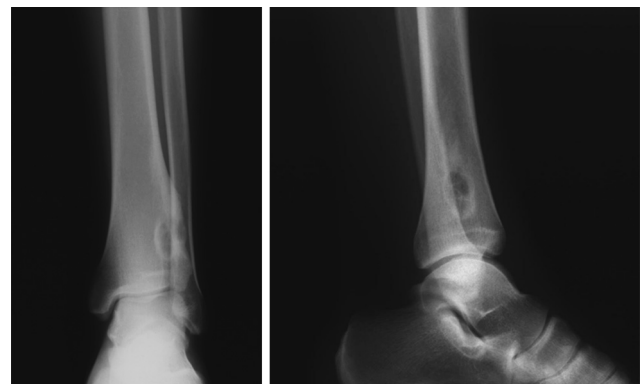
Anteroposterior and lateral plain radiographs of the left ankle performed in 2005 after accidental fall show well-defined osteolytic lesion with cortical reaction of the distal tibia, diagnosed as NOF.
